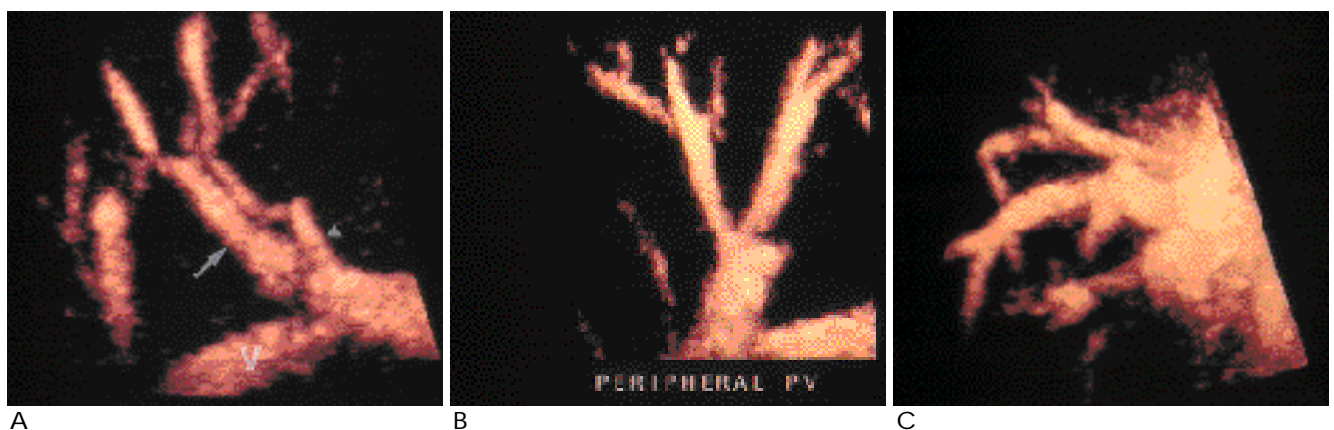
Three-dimensional power Doppler images (PDI) of hepatic vessels.
